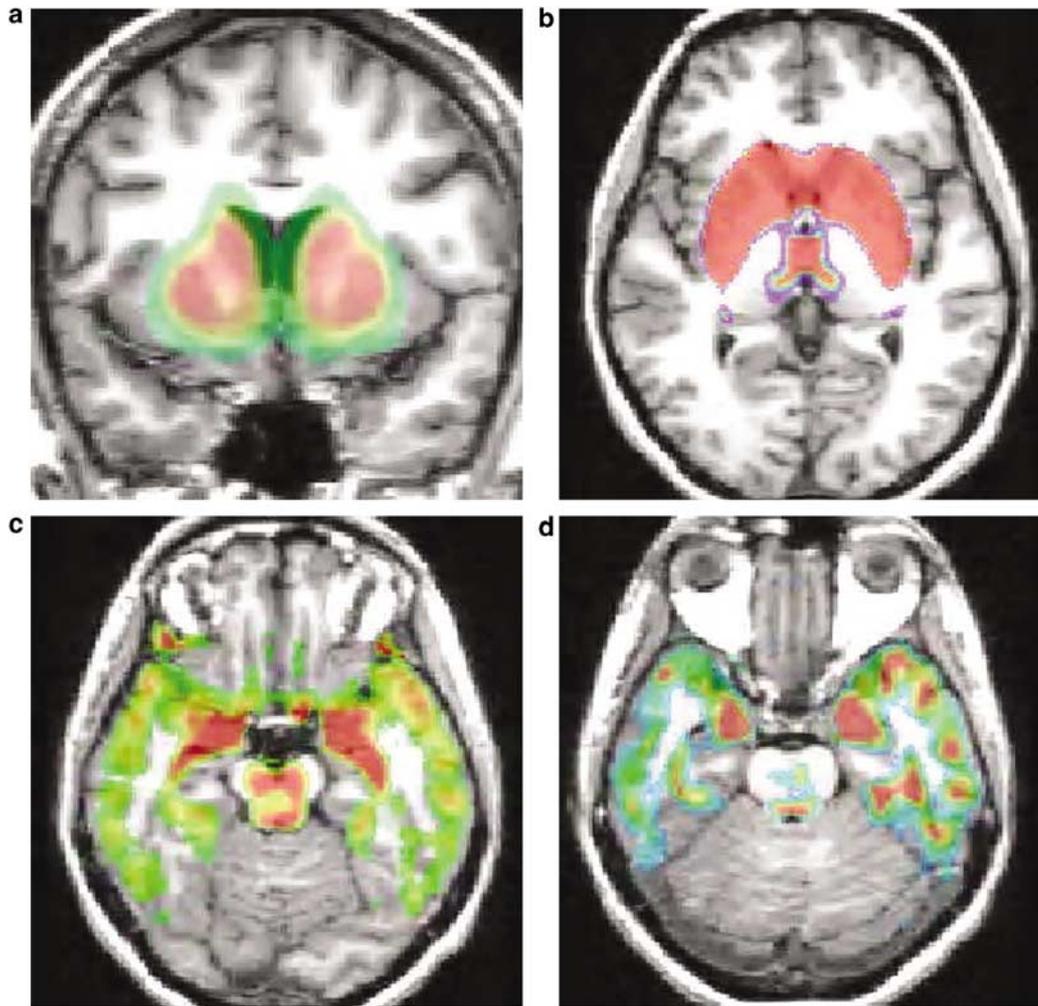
Parametric images of DA D2 receptor density coregistered with MRI images windowed to demonstrate [¹⁸F]fallypride-b.p.'s in (a) the anterior and ventral striatum on a coronal image, (b) the medial thalamus on an axial image, (c) the substantia nigra, colliculi, and temporal cortex on an axial image through the midbrain, and (d) the amygdala and temporal cortex on an axial image through the uncus of the temporal lobes.
